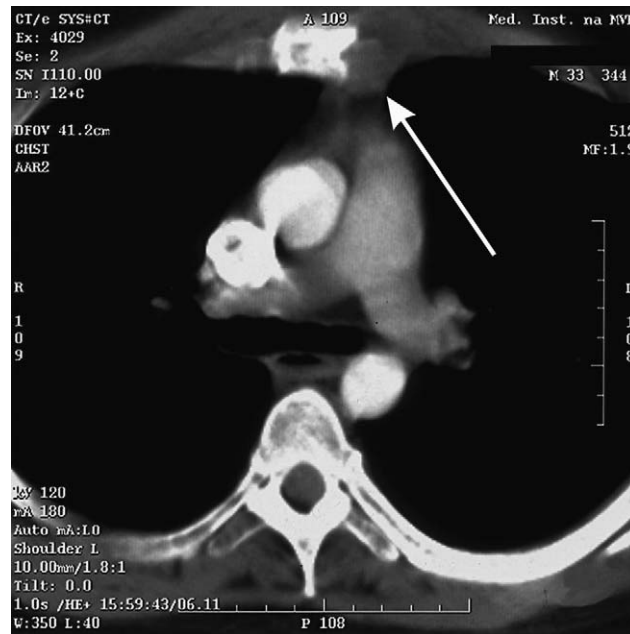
Contrast enhanced CT of thorax revealing a mass infiltrating the left border of the sternum.
